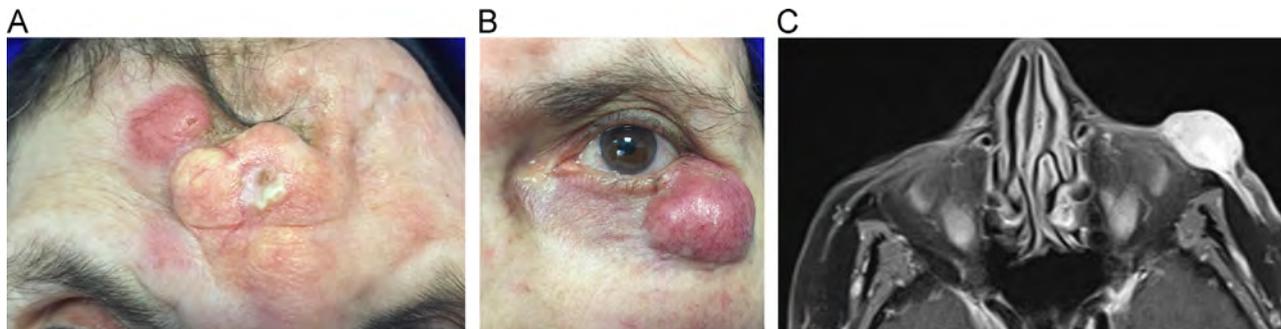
(A) The forehead lesion at presentation, which was biopsied and then treated with radiotherapy a year earlier. (B) The eyelid tumour was densely vascular and hard on palpation. (C) Orbital T1-weighted axial magnetic resonance imaging scan showed diffuse enhancement of the relatively well-delineated tumour after contrast agent administration.
